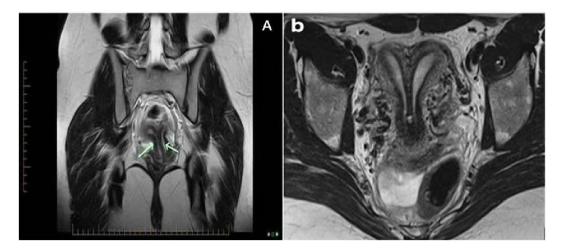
A: MRI showing didelphys uterus, B: MRI showing bi-cornuate uterus
